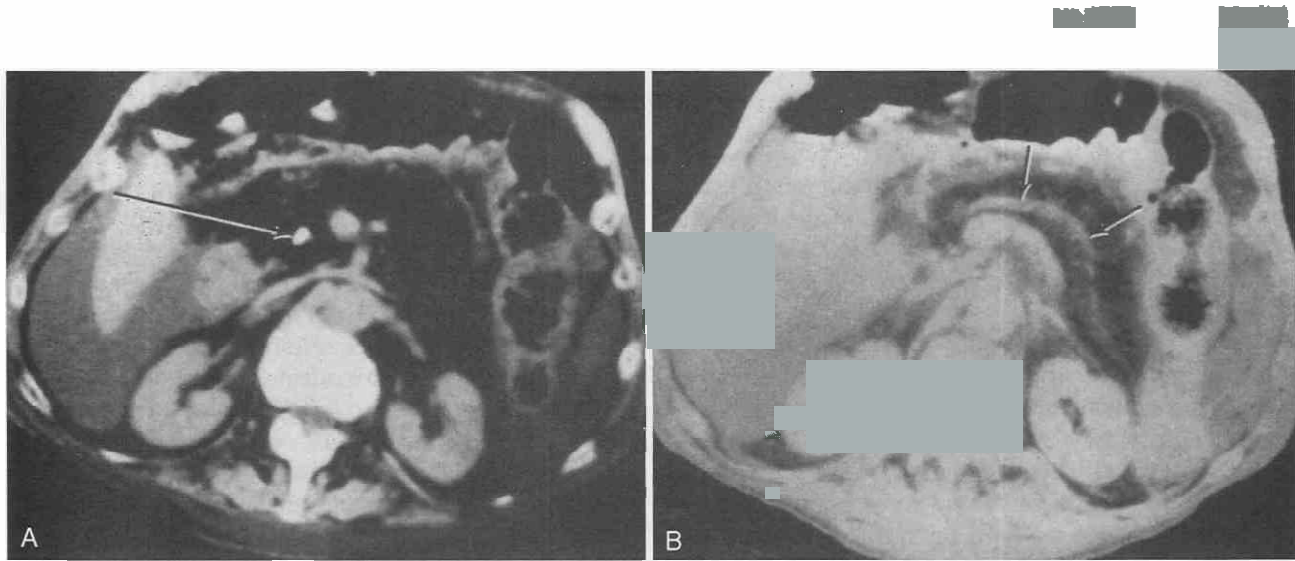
A, A calculus in the ampulla (arrow). B, Obstruction of the pancreatic duct (arrows) resulting from calculus. The pancreas has autolyzed so only the fat remains within the parenchymal area. (From Patel S, Bellon EM, Haaga J, et al: Fat replacement of the exocrine pancreas. AJR 135:843-845; copyright by American Roentgen Ray Society, 1980.)
